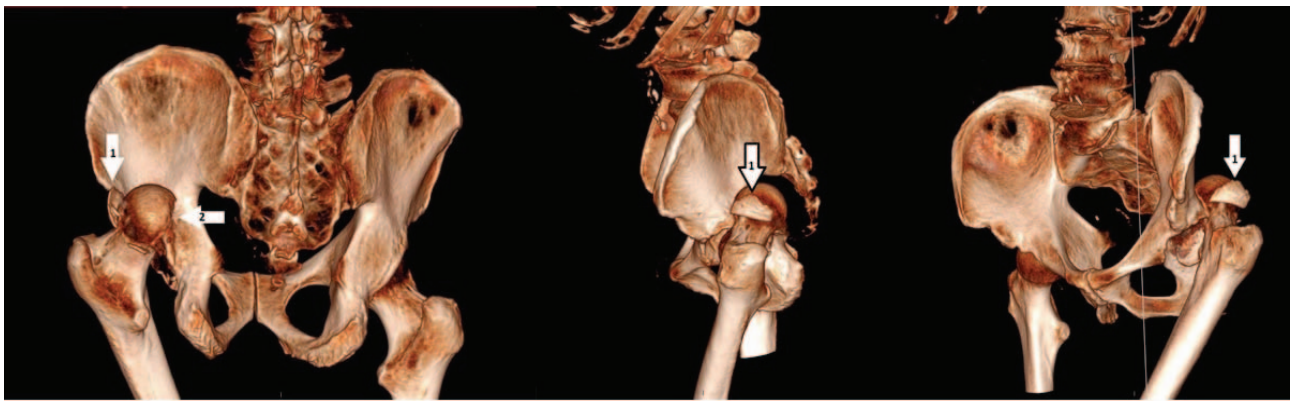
Computed tomography 3D reconstruction of the pelvis with both hips – the left hip without initial fracture of the femoral neck.
